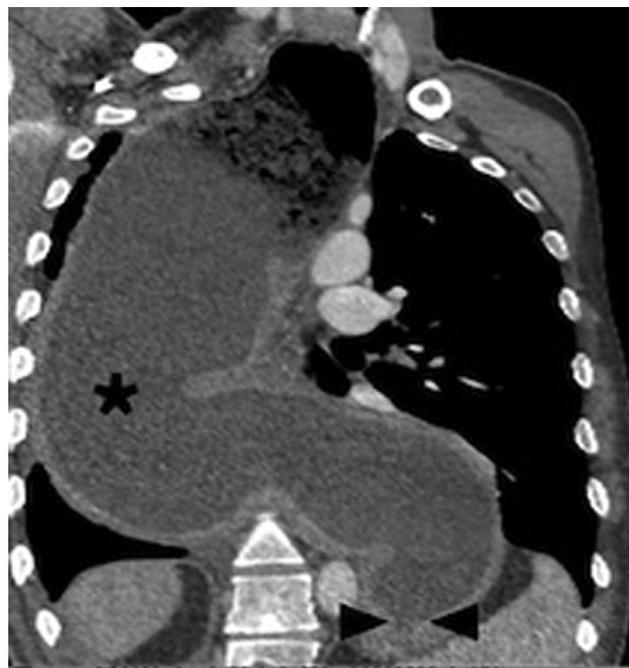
Multiplanar reformat CT demonstrates a markedly dilated and tortuous megaesophagus (asterisk), with proximal air-fluid level denoting distal obstruction. The dilated esophagus compresses and shifts the trachea anteriorly and to the right. The narrowed esophagogastric junction shows the classical "bird's beak", typical appearance of achalasia (arrowheads).
